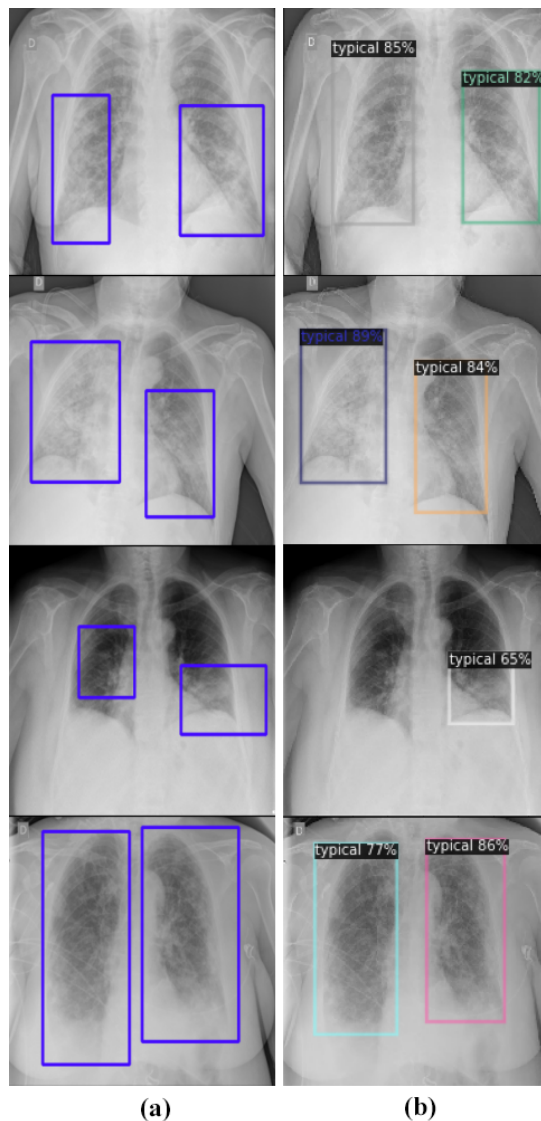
Chest X-ray images of COVID-19 patients.(a) ground-truth.(b) Prediction
